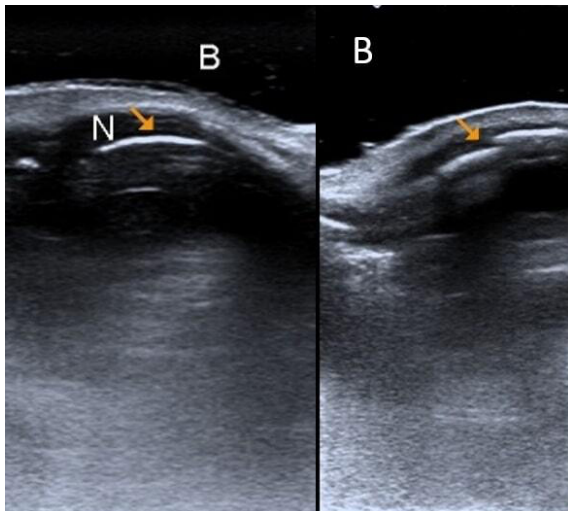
Nasal ultrasonography was performed using water balloon in supine position with 4-11 MHz linear probe
